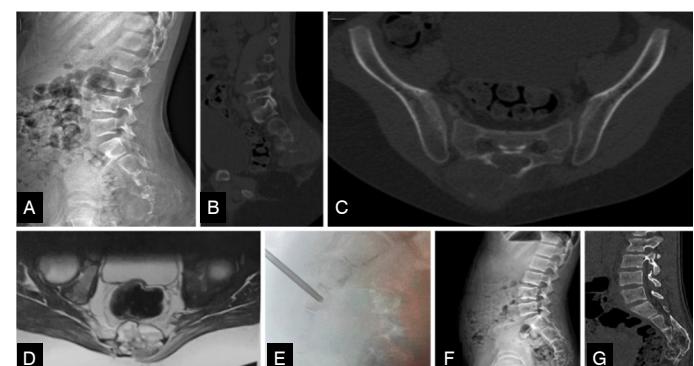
(Case 4) (A) Lateral radiograph of the lumbosacral spine showing the initial presentation of an aneurysmal bone cyst (ABC) in the sacrum. (B) and (C) display CT scans of the ABC, while (D) shows MRI. (E) shows the X-ray taken during intralesional injection of denosumab. (F) is a lateral radiograph of the lumbosacral spine taken 3 years after treatment, and (G) is a sagittal CT scan of the same region after the same follow-up period, both showing the ossified lesion.
